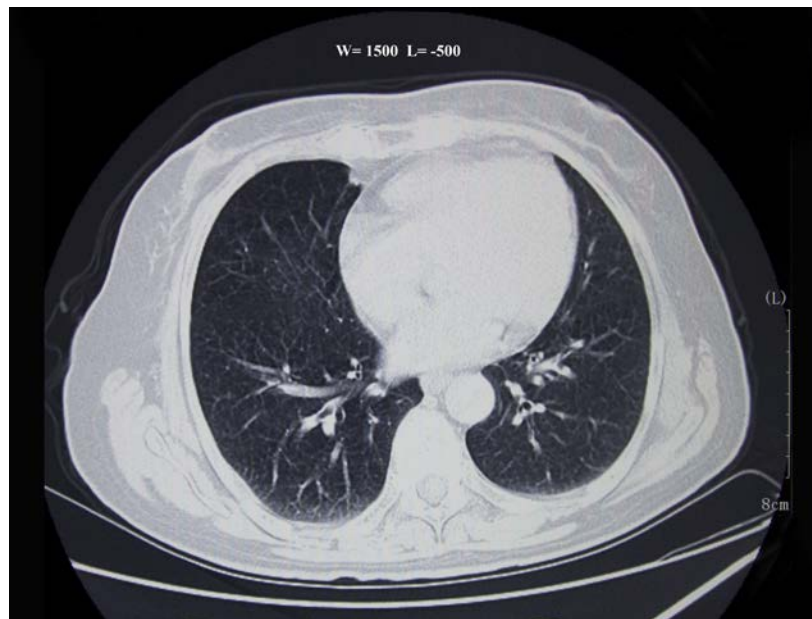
Axial CT image of chest (lung window).
